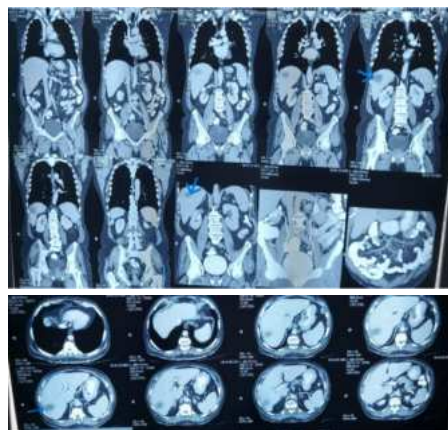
Contrast enhanced computed tomography of thorax and abdomen showing residual liver abscess in segment VII of right lobe of liver (blue arrows)
